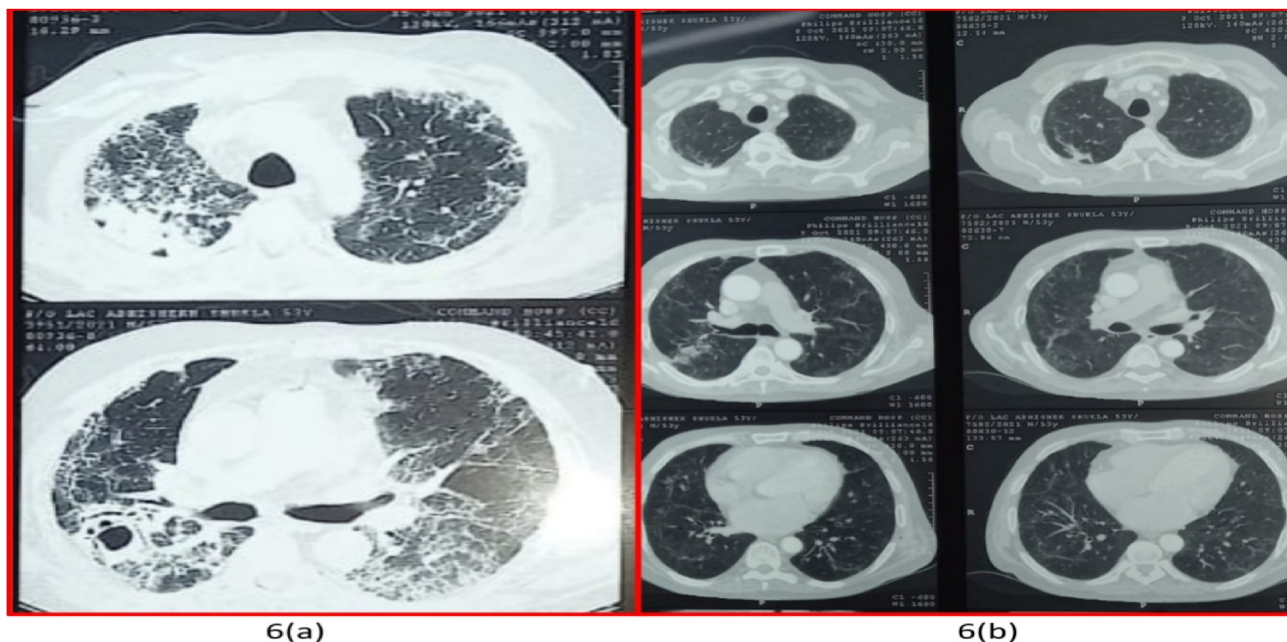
Patient no 1, a case of renal transplant recipient with post-COVID fungal pneumonia. (a) CT chest showing cavity RML. (b) Follow-up CT after 6 weeks. (c) CT after 6 months showing significant resolution of disease.
